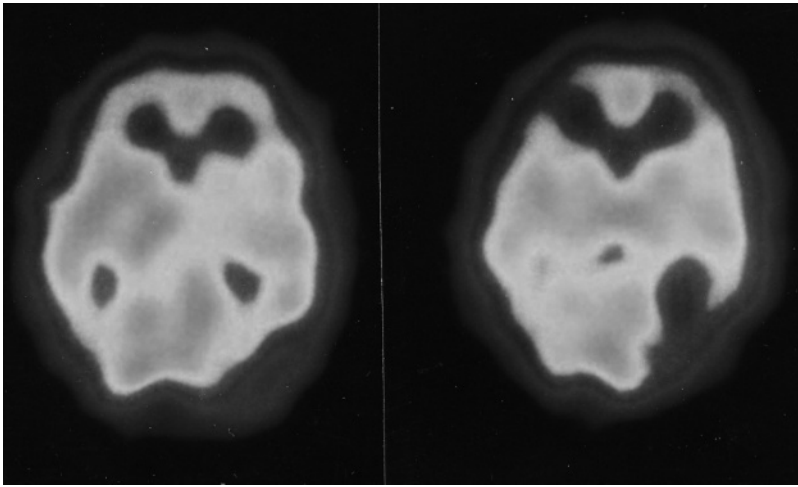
SPECT scan showing thalamic hypoperfusion in a case of central pain of thalamic origin. Propofol (0.2 mg/kg IV bolus) renormalized the asymmetry and allayed the pain. See color plate section.
